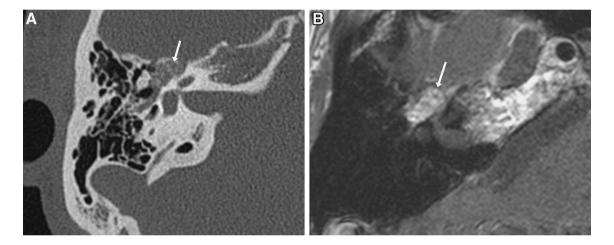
Geniculate venous malformation. a Axial CT image in bone algorithm shows an expansile lobulated mass centered at the geniculate ganglion, with internal foci of bony spicules (arrow). b Axial
